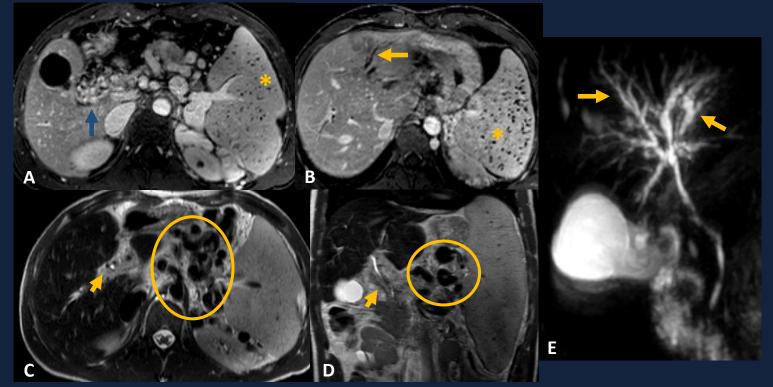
29-year old male patient with portal cavernoma. (A) and (B) Axial contrast-enhanced T1-weighted MR images demonstrating serpiginous portal cavernoma (blue arrow) with consequent intra-hepatic bile ducts dilatation (yellow arrow). Additionally, splenomegaly and siderotic foci (*) are seen within the spleen (Gamna-Gandy bodies) in association with portal hipertension. (C) Axial and (D) coronal T2-weighted MR images demonstrate the portal cavernoma compressing the main bile duct (arrow). Splenic varices (circle) are also visible due to elevated pressure in the portal venous system. (E) MRCP image demonstrate multiple irregularities of intra-hepatic bile ducts (arrows).
